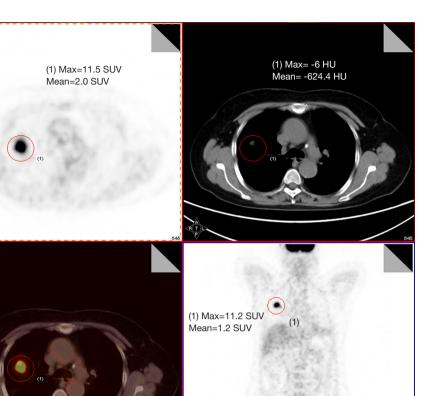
One patient's chest CT image with a solid tumor.
